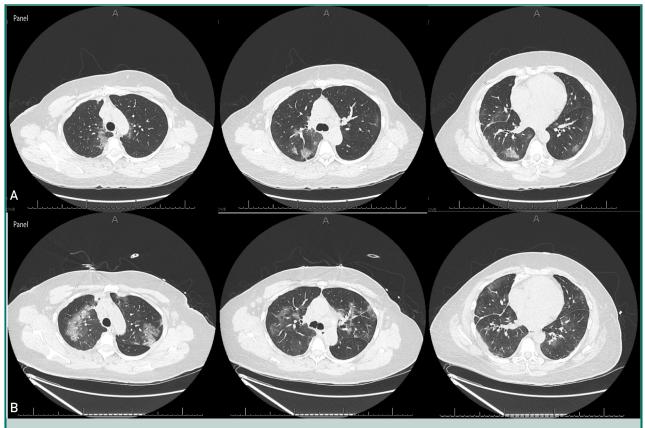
Axial computed tomography chest images on day 7 (day of admission, A) and day 17 after symptom onset (B), showing new and migratory lung infiltrates suggestive of organizing pneumonia.
